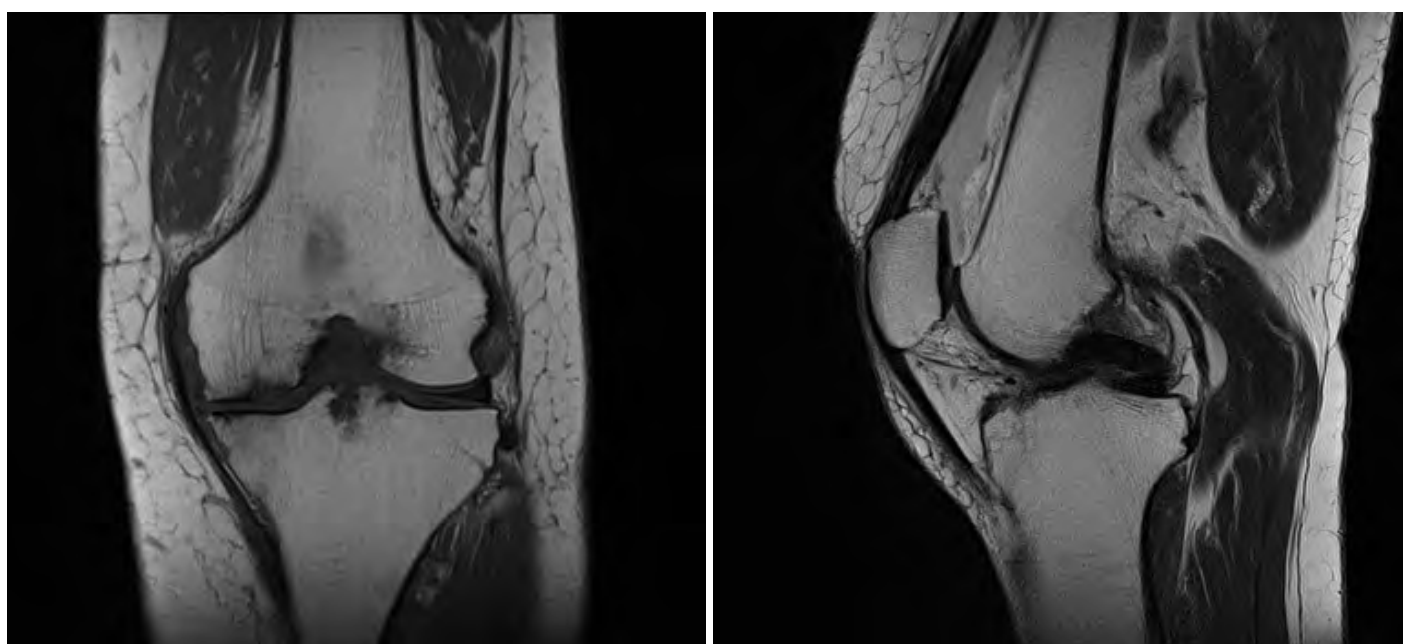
Pre-operative MRI image of patient's left knee.
